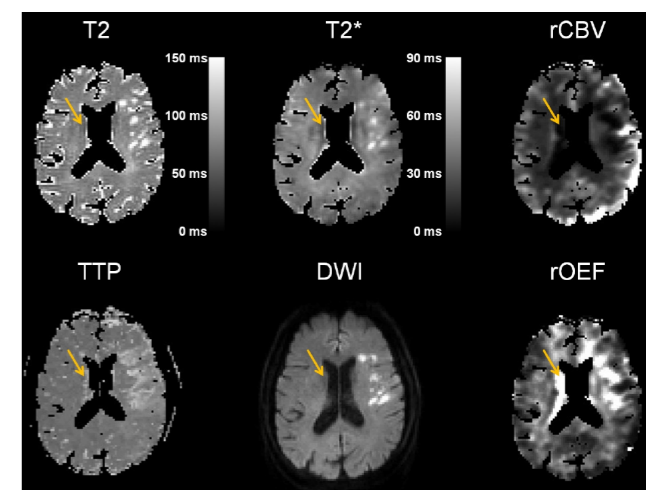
Single slice in a patient with subacute ischemic stroke. Input maps for rOEF calculation (T_2 , T_2^* , rCBV) are shown at the top. Time to peak (TTP) and diffusion weighted (DWI) images are shown for comparison of visible ischemic areas with potentially hypoxic areas. The arrow marks a potentially hypoxic area contralateral to the ischemic core. Figure from [6].
